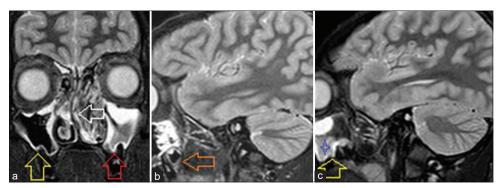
Magnetic resonance imaging short-tau inversion recovery sequences. (a) Coronal section shows peripheral hyperintensity with central hypointensity in the left maxillary sinus (red arrow). The right maxillary sinus shows mucosal hypertrophy (yellow arrow). (b) Sagittal section through the right maxillary sinus shows mucosal hypertrophy (red arrow) and (c) through the left maxillary sinus, reflects the hyperintense lesion with central hypointensity (yellow arrow)
